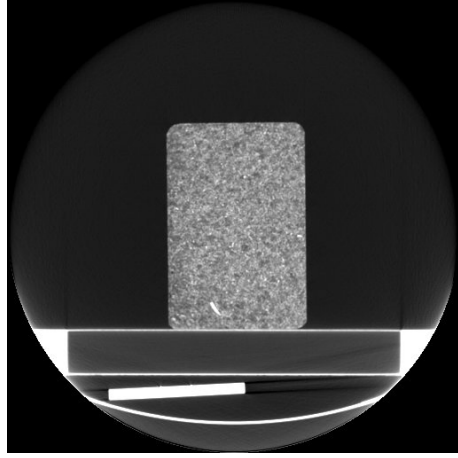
CT scan of the Christchurch Hospital Cork block.
